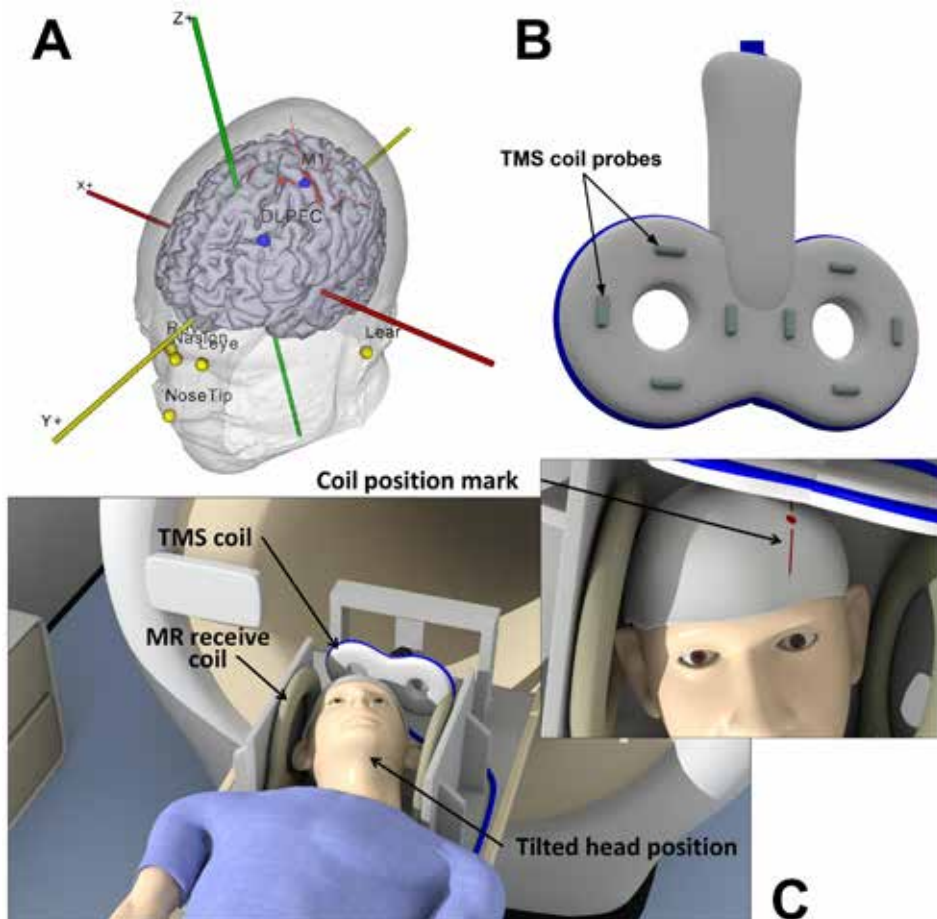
Panel A Location of facial markers and TMS targets in the Neural Navigator. Facial markers: the tip of the nose; nasion, left and right inner eyelid; left and right upper and lower ear. TMS targets: the primary motor cortex (M1); dorsolateral prefrontal cortex (DLPFC). The DLPFC is located in the middle frontal gyrus, 3cm anterior to the premotor area. Panel B. TMS coil probes. The probes can be visualized in a T2-weighted scan to determine their location with respect to the head. Panel C. Participant is lying on the MR bed with the head positioned in between two MR receive coils and the TMS coil located over the cranium. The TMS coil is oriented perpendicular to the static magnetic field of the MRI scanner to minimize Lorentz forces in the coil. The head is tilted in order to position the TMS coil over the left DLPFC. (In the published variant: Figure 2)
